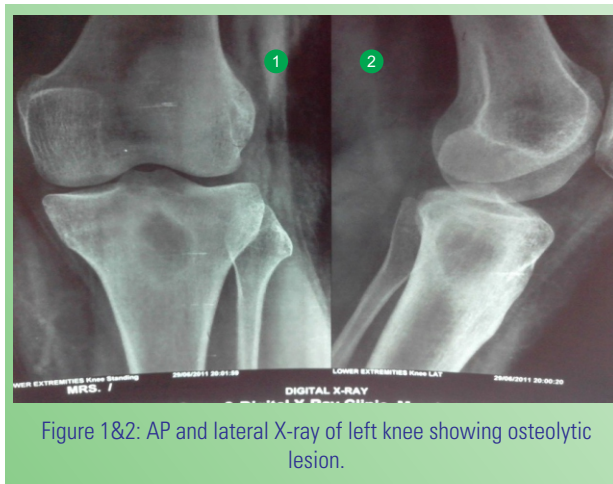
AP and lateral X-ray of left knee showing osteolytic lesion.
